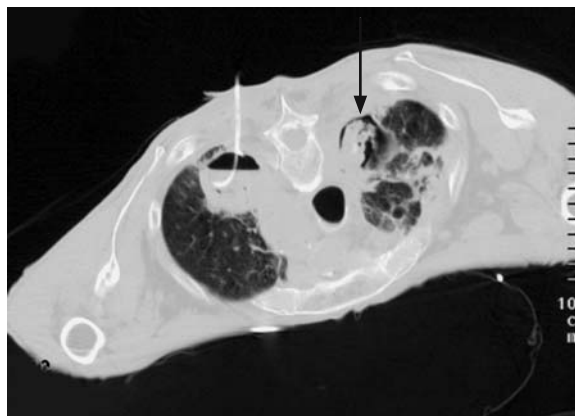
CT-guided percutaneous infusion of antifungal medication into a mycetoma containing left upper lobe cavity. Note contralateral aspergilloma (arrow) that was treated at a later date
